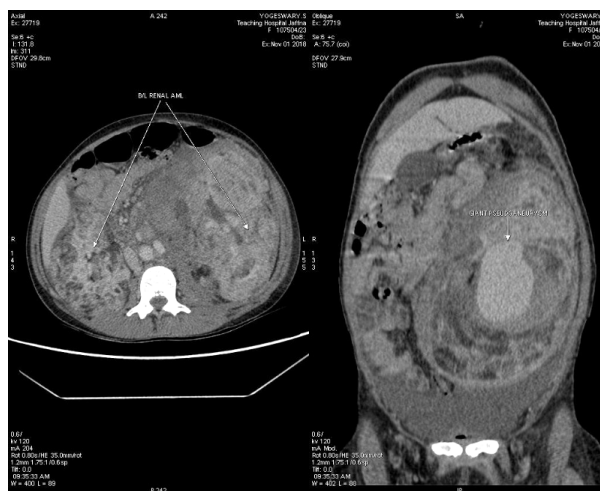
CT angiogram showing bilateral renal multiple angiomyolipomas with left intra-renal pseudoaneurysm. Axial and coronal views.
